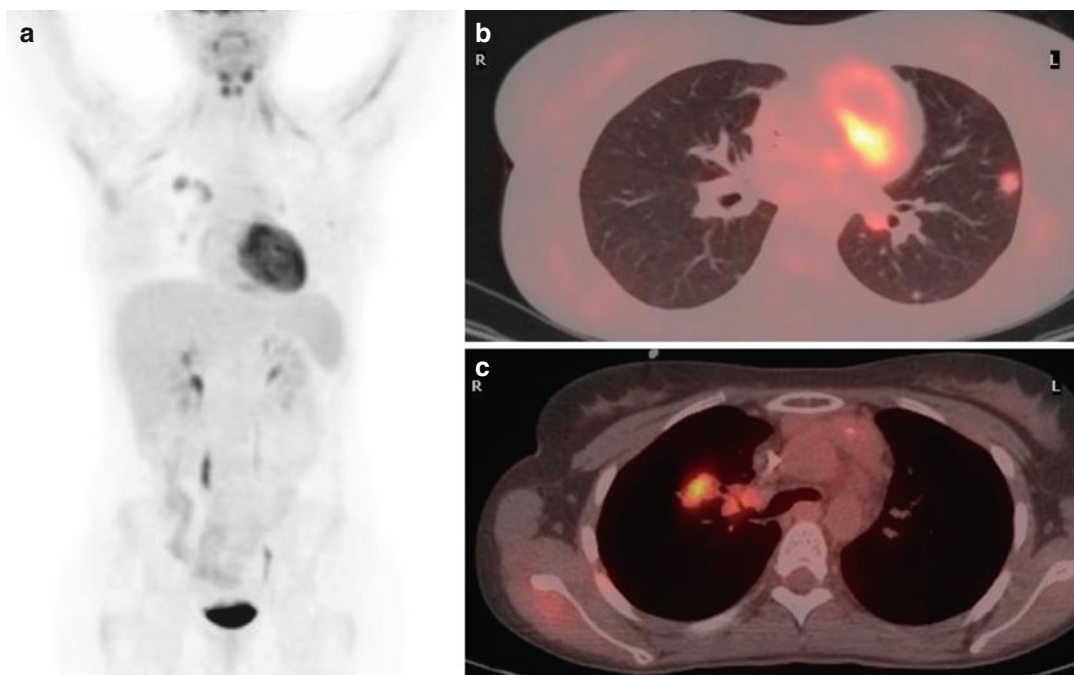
(a–c) PET/CT three months later after BEAM high-dose therapy and ASCT revealed progressive disease with new lung nodules and new findings in right hilar and left peribronchial nodes (a–c)
